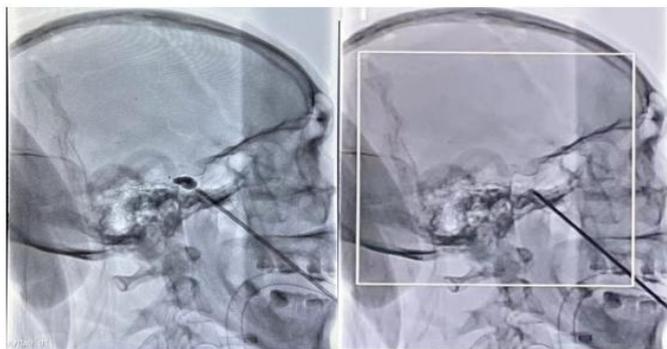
shows the lateral X-ray fluoroscopy view during the operation that the cannula needle successfully punctured into the inner foramen ovale (A). Lateral X-ray fluoroscopy shows that the balloon is "pear-shaped" (B).
